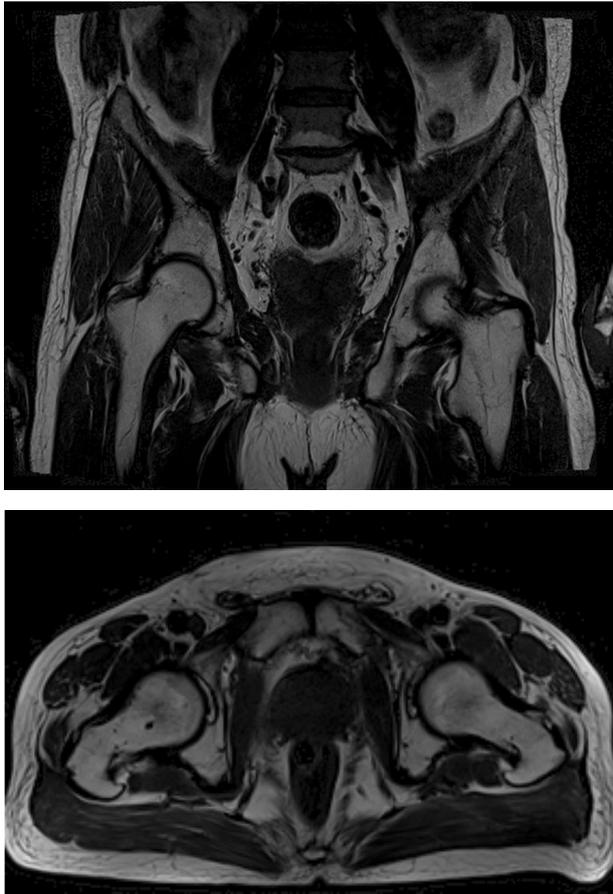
Postoperative Magnetic Resonance Imaging of Pelvis (sagittal and axial scans)
